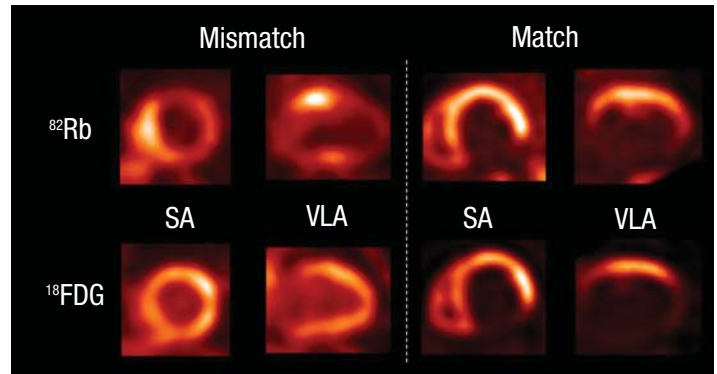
PET viability patterns in two different patients with ischemic cardiomyopathy. Perfusion/metabolism mismatch with reduced Rb-82 uptake (perfusion) but preserved F-18 FDG metabolism indicating hibernating myocardium in lateral and apical wall is shown on left. On right, a matched defect, indicating scar, is shown in inferior myocardium.
